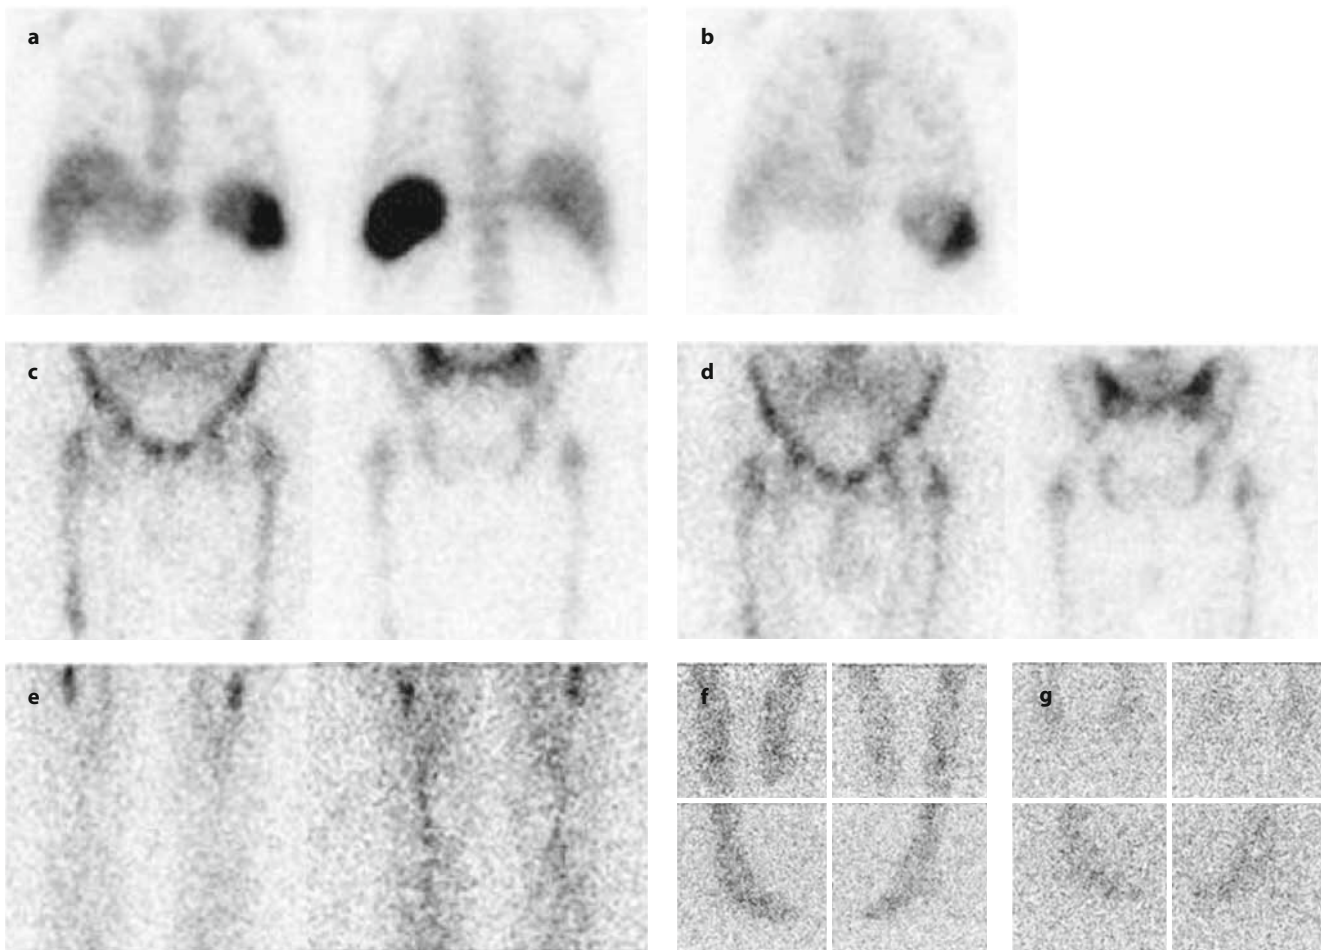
^{111}In -oxine-leukocyte scintigraphy. Planar spot views of the chest obtained 4 hours (a) and 24 hours (b) after injection. Early localization in the liver, spleen and bone marrow (a), decreasing over time (b). Planar anterior and posterior spot views of the pelvis obtained 4 hours (c) and 24 hours (d) after injection show localization in the bone. Planar anterior and posterior views of the femora (e) obtained 24 hours after administration show bone marrow radiolabeled leukocyte uptake at the proximal portion of both femoral diaphyses. Planar spot views of the feet obtained 4 hours (f) and 24 hours (g) after injection obtained in anterior, posterior (*upper panels*) and lateral views (*lower panels*)
